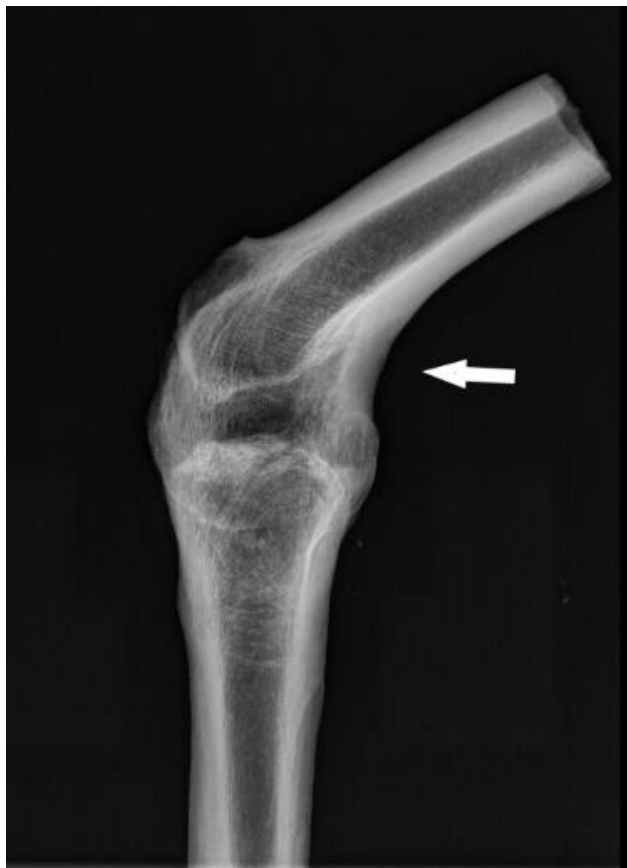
Part of the upper and lower right leg (femur and tibia), completely fused x-ray
